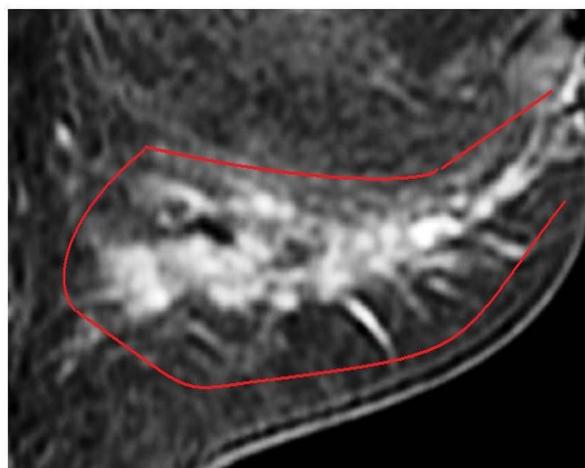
Breast MRI. *Segmental* contrast enhancement pattern of a DCIS lesion.
